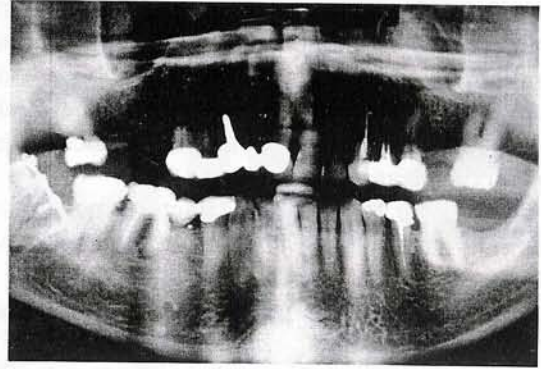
Transoral Approach; X-ray
